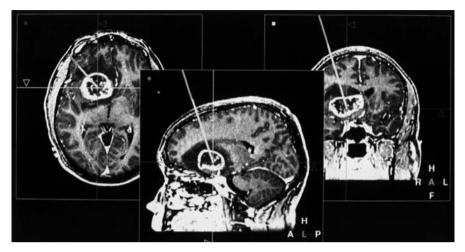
Target planning in axial, sagittal and coronal planes from MRI scan using neuronavigation ("frameless stereotaxy"): the lesion was a glioblastoma
